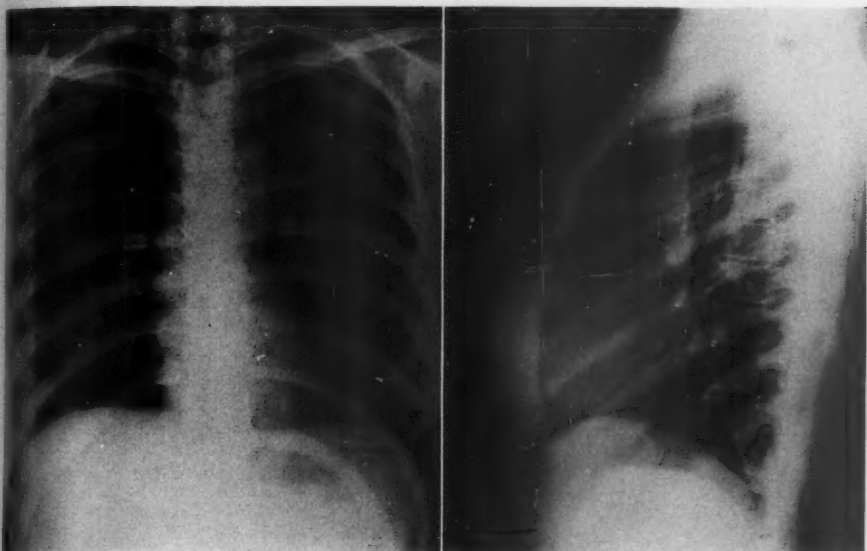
Sarcoid*. Routine posteroanterior and lateral chest x-rays of a 26-year-old white woman who had no symptoms whatever. Skin tests were negative. At operation the left hilar mass turned out to be a mass of granulomatous lymph nodes showing the characteristic noncaseating tubercles of sarcoidosis (B). No organisms could be visualized. (From Peabody *et al.*, *J. Thor. Surg.* 35: 384, 1958.)
